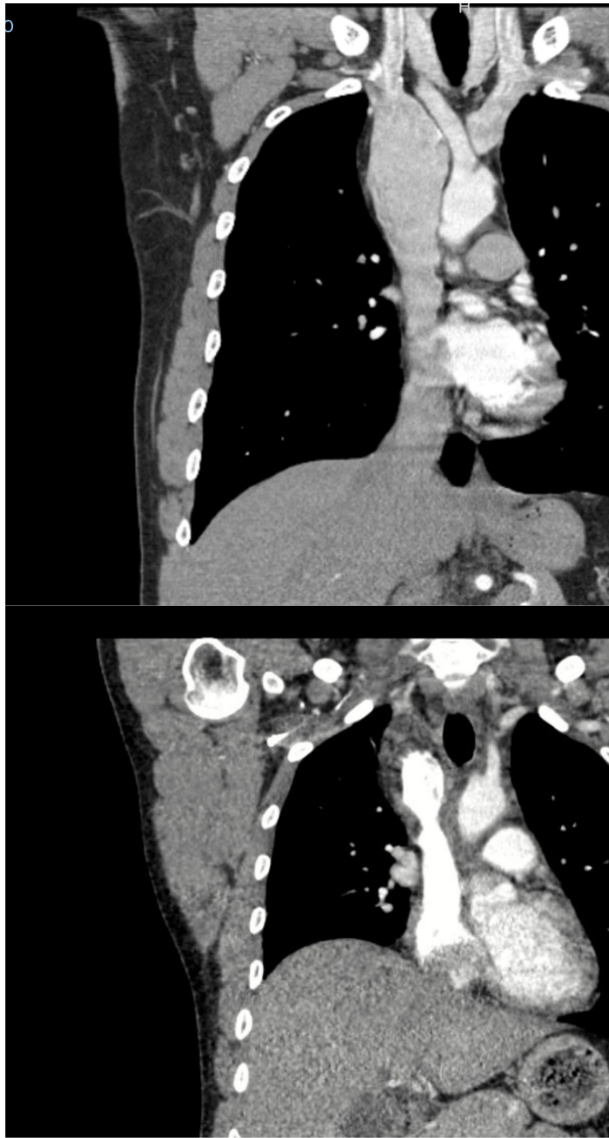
Contrast-enhanced chest computed tomography. Upper: Preoperative coronal CT. Lower: Postoperative coronal CT.
